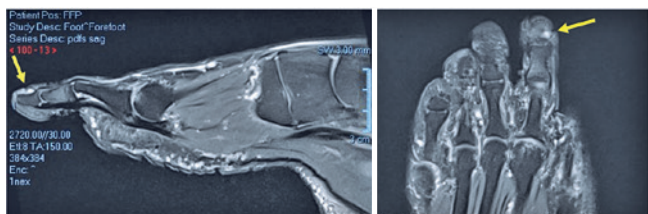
Sagittal and coronal magnetic resonance images showing a dorsomedial hyperintense lesion on the second toe.
